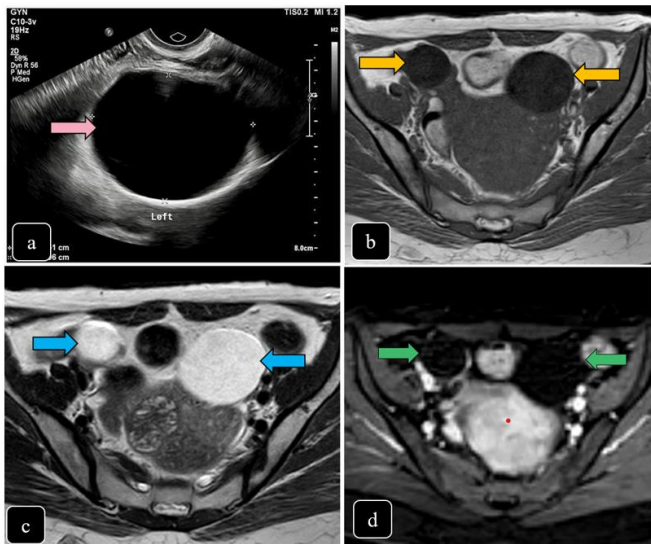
(a) Transvaginal ultrasound shows a cystic lesion (pink arrow) in bilateral adnexa with no evidence of internal
